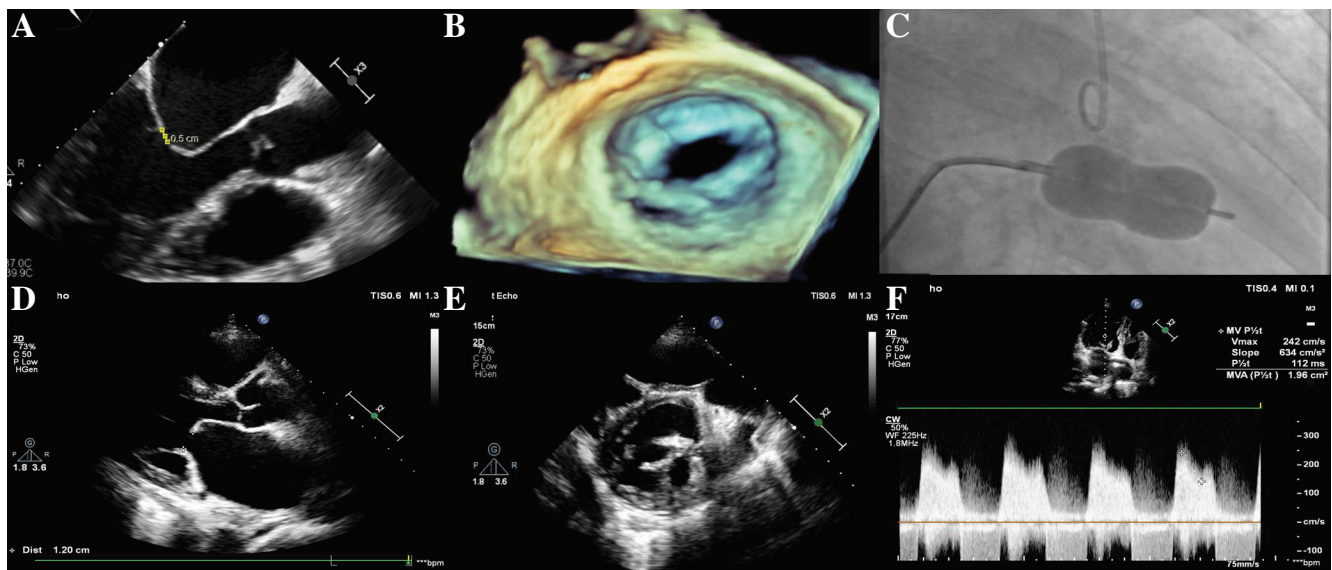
Mitral valve images before and after percutaneous mitral balloon valvuloplasty. A. The distance between the mitral valve leaflets before the procedure. B. Transesophageal echocardiographic image of the mitral valve before the procedure. C. Angiographic image of percutaneous mitral balloon valvuloplasty. D. The distance between the mitral valve leaflets after the procedure. E. Transesophageal echocardiographic image of the mitral valve after the procedure. F. Echocardiographic measurement of the mitral valve area using the pressure half time method.
